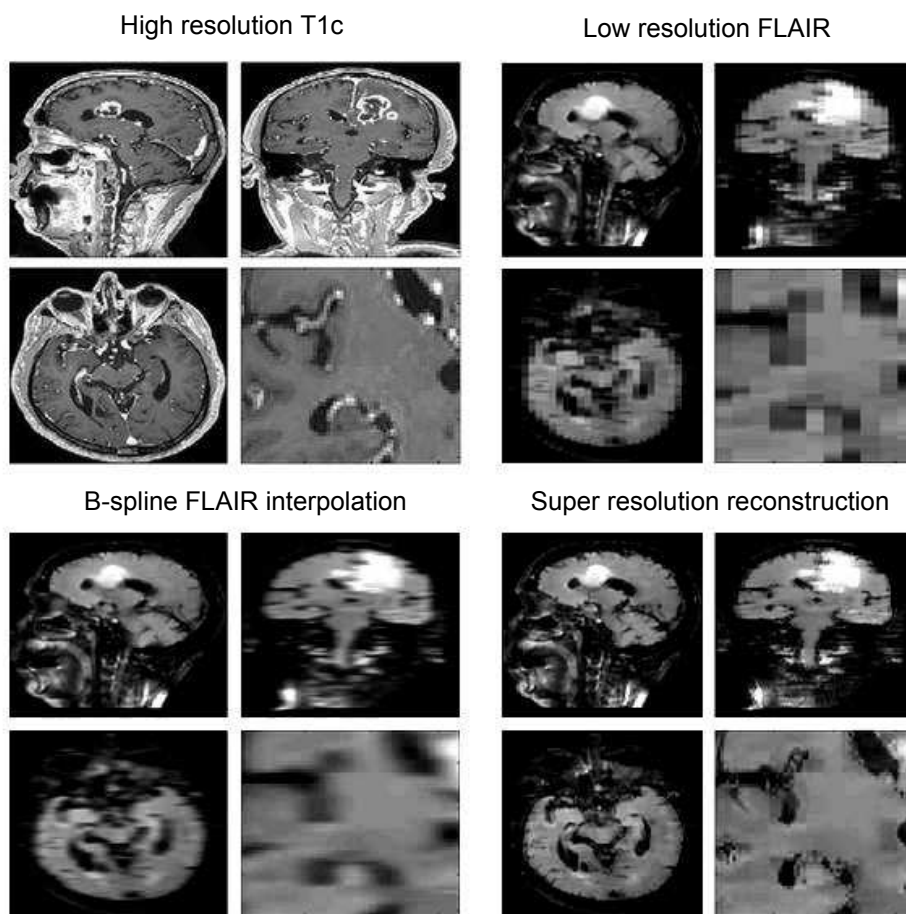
Example of super resolution reconstruction of a low resolution FLAIR sequence using information of a high resolution T_{1c} sequence from the same patient. Comparison between classic b-spline interpolation of the low resolution FLAIR sequence and the super resolution reconstruction.
